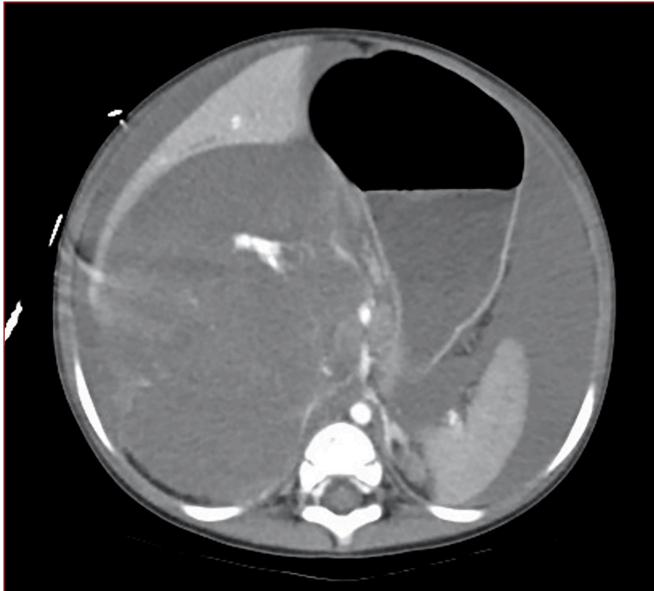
A computed tomography scan of the abdomen on the second day of hospitalization. The image reveals massive ascites with a small abdominal aorta, which is compatible with the status of hemoperitoneum.
